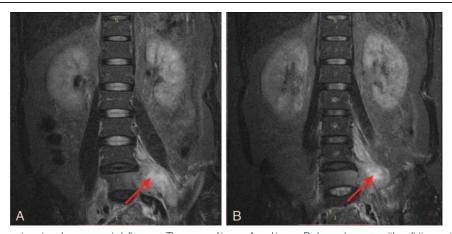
Magnetic resonance imaging shows mass in left psoas. The arrow of image A and image B showed a mass with soft tissue signal in the left psoas. Long T1 and T2 signal was displayed in the left of 5th lumbar vertebral, and a mass $(6.9 \, \text{cm} \times 4.1 \, \text{cm})$ with soft tissue signal was shown in the left psoas. The diagnosis of the MRI scan findings maybe the TB infection with cold abscess.
